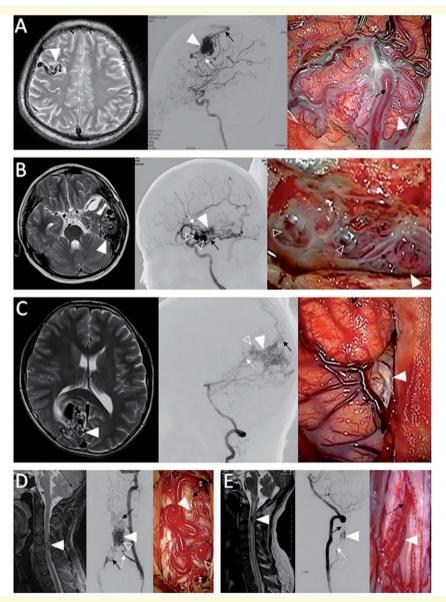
Representative MRI T₂-weighted, digital subtraction angiography (DSA) and intraoperative images of BAVMs/SAVMs included in this study. (A) Patient 2, right frontal lobe BAVM, KRAS p.G12D, ddPCR variant frequencies = 5.61%. (B) Patient 16, left temporal lobe BAVM, BRAF p.V600E, ddPCR variant frequencies = 2.99%. (C) Patient 17, occipital lobe BAVM, negative. (D) Patient 1, cervical SAVM, KRAS p.G12D, ddPCR variant frequencies = 4.40%. (E) Patient 21, cervical SAVM, BRAF p.V600E, ddPCR variant frequencies = 7.29%. Typical dark flow void signal on the MRI T₂-weighted images (*left*) indicate the niduses (white arrowhead) of arteriovenous malformation, which are surrounded by feeding arteries and draining veins. Feeding arteries (white arrow), nidus (white arrowhead), draining veins (black arrow) and high risk structure (white hollow arrowhead) can be identified clearly on the DSA (*middle*). Intraoperative images (*right*) demonstrate the tortuous dilated vessels on the surface of brain/spinal cord, of which the feeding arteries, nidus (white arrowhead), high risk structure (white hollow arrowhead) can be recognized easily.
